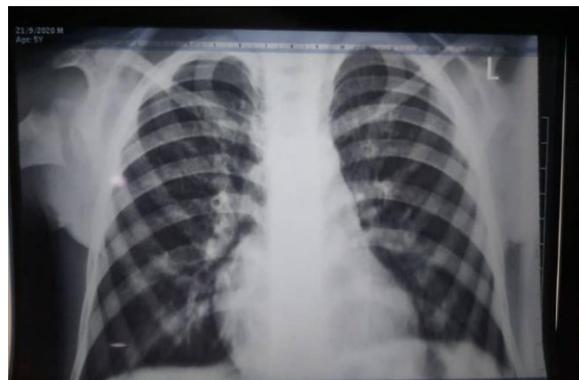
C Xray showing, interstitial shadowing in the upper, middle lung zones with accentuations of broncho-vascular markings.
